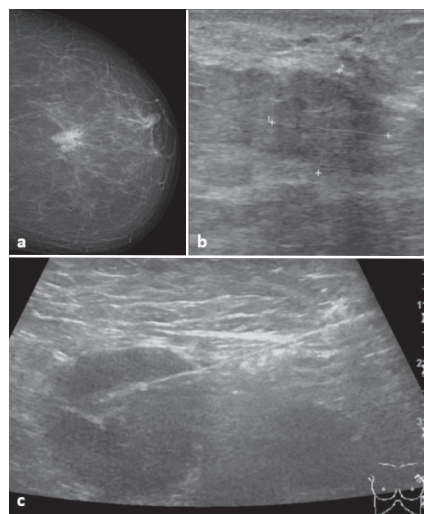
62-year-old woman with a BI-RADS 5 lesion on a mammography and b ultrasound. Benign papilloma without atypia was diagnosed with ultrasound-guided biopsy, whereas biopsy of a suspicious lymph node in the left axilla (c) revealed a metastasis of an invasive carcinoma. Subsequent surgical excision of the breast lesion confirmed this diagnosis.
